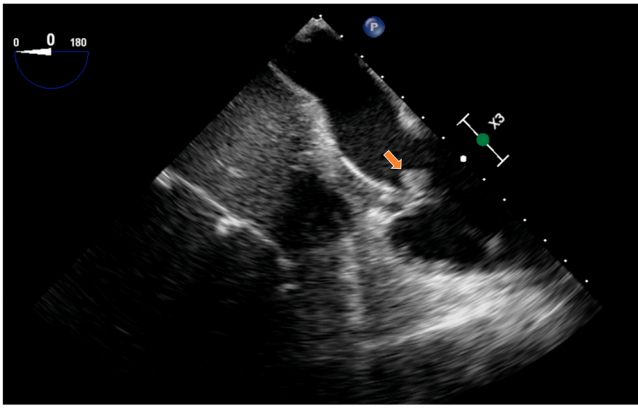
Tricuspid valve vegetation on transthoracic echocardiogram.
